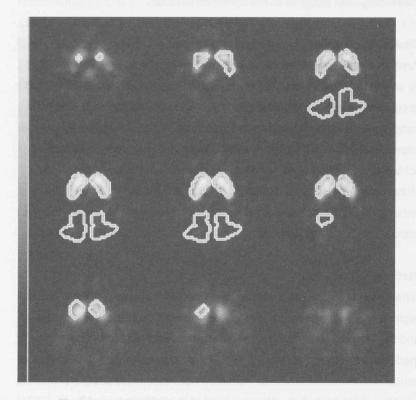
[<sup>123</sup>I]FP-CIT SPECT images of an antipsychotic-naive patient with schizophrenia. Transverse slices of the striatum with overlaid Volumes of Interest for striatum and occipital cortex. The level of radioactivity is color encoded from low (black) to high (white). Colour version on the inside of the cover.
